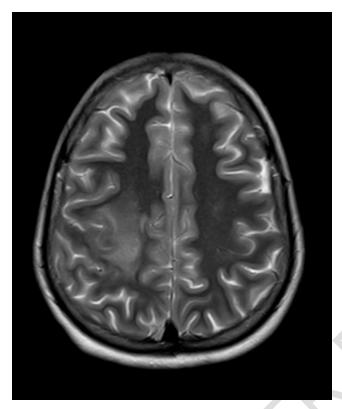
MRI brain showing patchy enhancement of precentral gyrus with perilesional white matter edema
